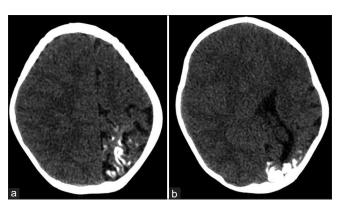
A 4-year-old female child with Sturge-Weber syndrome had a history of convulsions. Axial CT (a and b) shows left-sided cerebral hemiatrophy with gyral calcifications and associated enlargement of ipsilateral choroid plexus
